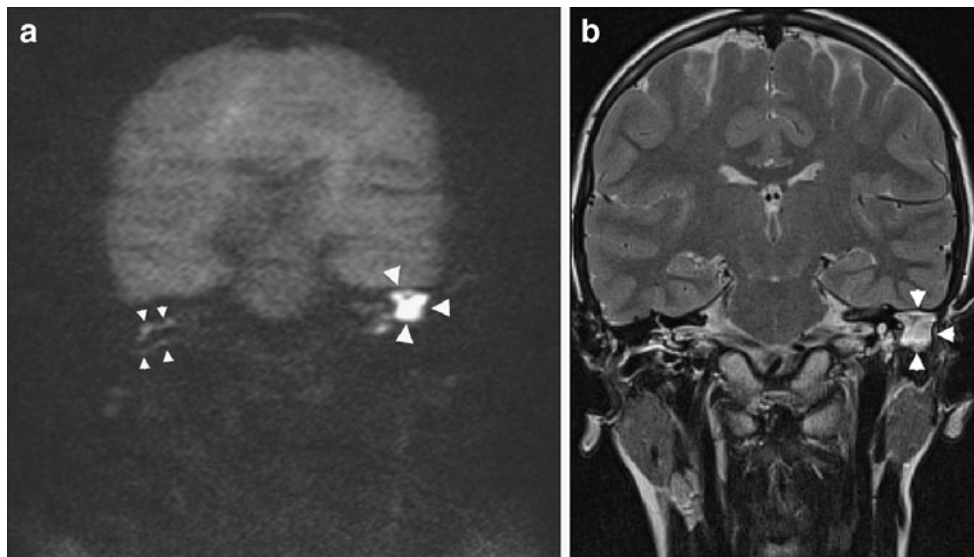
A 41-year-old male with a large cholesteatoma on the left side. MR imaging performed in a preoperative setting. a Coronal non-EP DW b1000 image (SS TSE DW sequence or HASTE DW sequence). Large nodular hyperintensity on the left side (*large arrowheads*) compatible with a large middle ear cholesteatoma. There are two linear hyperintensities on the right side (*small arrowheads*). b Coronal 2-mm-thick TSE T2-weighted image at the level of the internal auditory canal demonstrating the large middle ear cholesteatoma on the left side (*large arrowheads*). Note that the linear hyperintensities
